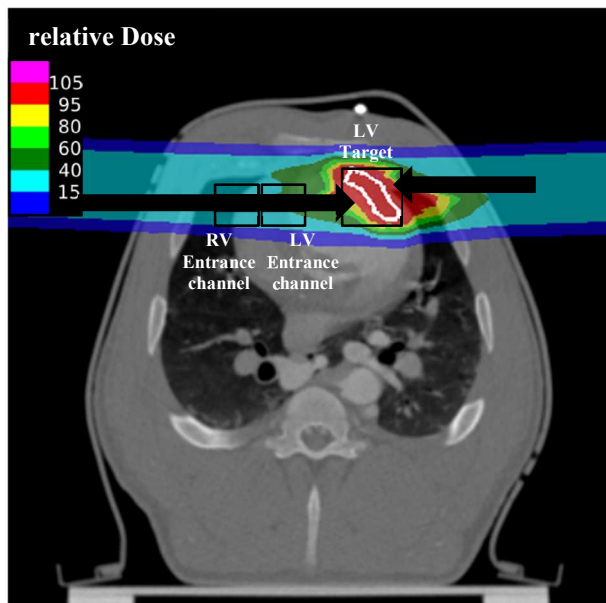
CT scans of the heart with exemplary dosecuts from the axial (left) view of a left ventricular target irradiated with a dose of 40 Gy. Modified from (Erbeldinger et al., 2015).
